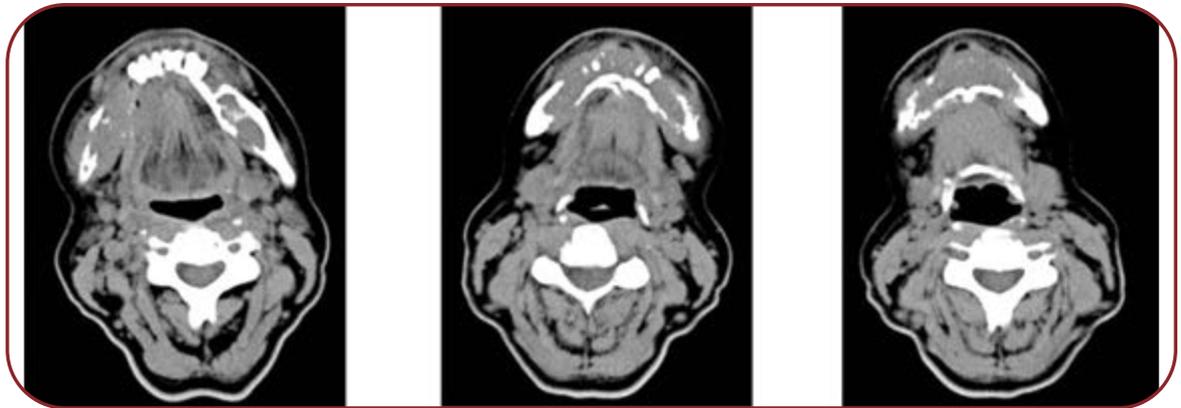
CT axial images of the tumor involving the mandible
